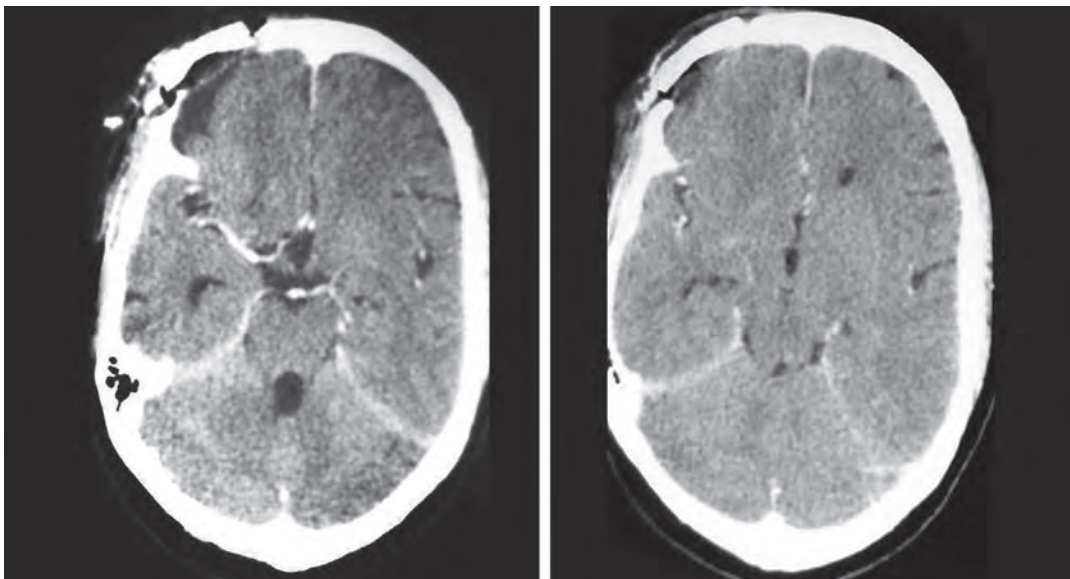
Post-operative contrast CT scan of the brain showing evidence of craniotomy and total excision of the lesion with post-operative changes
